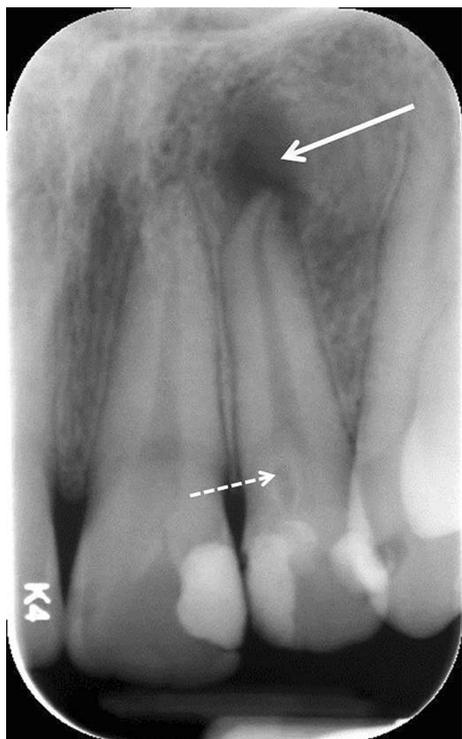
Intraoral periapical radiograph. A relatively well-defined periapical inflammatory lesion is present on the lateral incisor (*solid arrow*). The high resolution of this modality is adequate to depict the lack of lamina dura at the apex of the involved tooth. The differential diagnosis of a periapical inflammatory lesion is granuloma, inflammatory cyst, or abscess. Note the invagination referred to as dens in dente (*dashed arrow*) in the same tooth; dens in dente often results in a periapical inflammatory lesion
